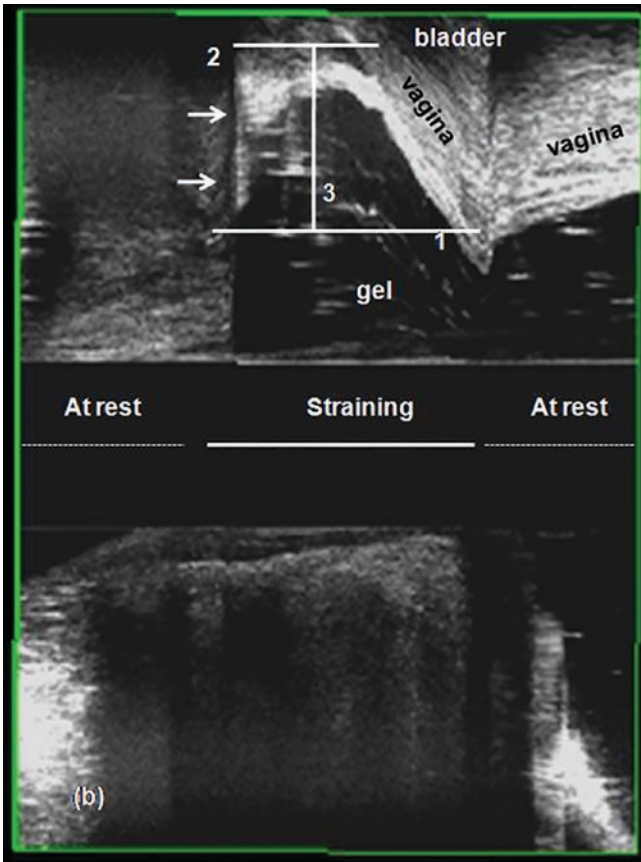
Dynamic 360-degree endoanal ultrasound with ultrasound gel in the rectum showing an anterior rectocele
